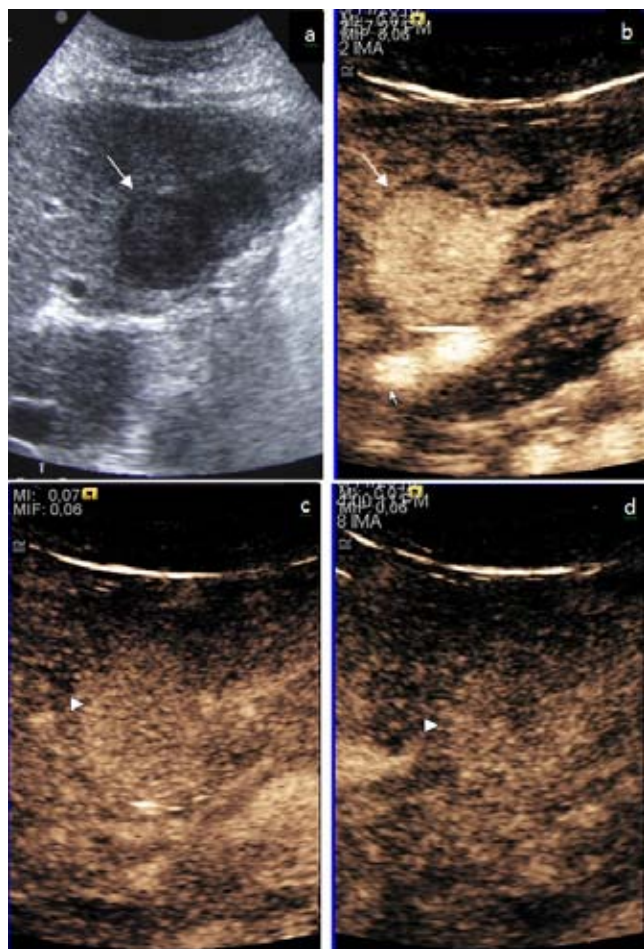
Grey scale (a) sonography of the mass studied by CEUS showing a well defined isoechoic lesion (arrow) with a halo in the left lobe of liver. CEUS was performed for characterisation of the mass. Arterial phase(b) of CEUS showing enhancement of the mass at 10 seconds (white arrow) followed by retained contrast (white arrowhead) on venous phase (c) [90 seconds] with relative washout (white arrowhead) on the delayed phase (d) [132 seconds] suggesting the classical enhancement pattern of hypervascular HCC.
